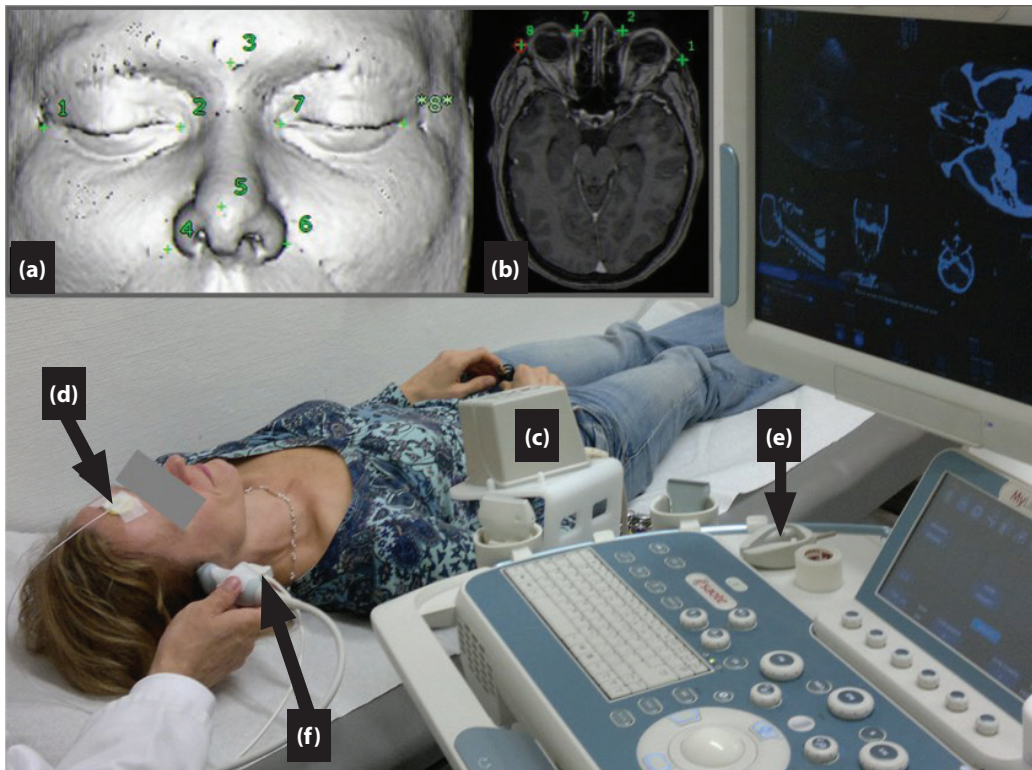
Ultrasound fusion imaging (UFI) system setup and matching: patient and investigator position for routine transcranial UFI. (a) 3D-surface-rendered head image: green numbered stars indicate the chosen external marker points of a T1-MRI-dataset derived from a conventional 1.5 Tesla MRI scanner (outer and inner eye corners, nose and forehead); (b) single MRI image of a 3D-reconstructed dataset with localization of external marker points; (c) electromagnetic field emitter orientated towards the patients head; (d) motion control sensor fixed by adhesive tape to the patient's forehead; (e) registration pen with slot for temporary attachment of the second electromagnetic field sensor; (f) Conventional transcranial color-coded sonography (TCCS) probe with attached electromagnetic field sensor during examination .
